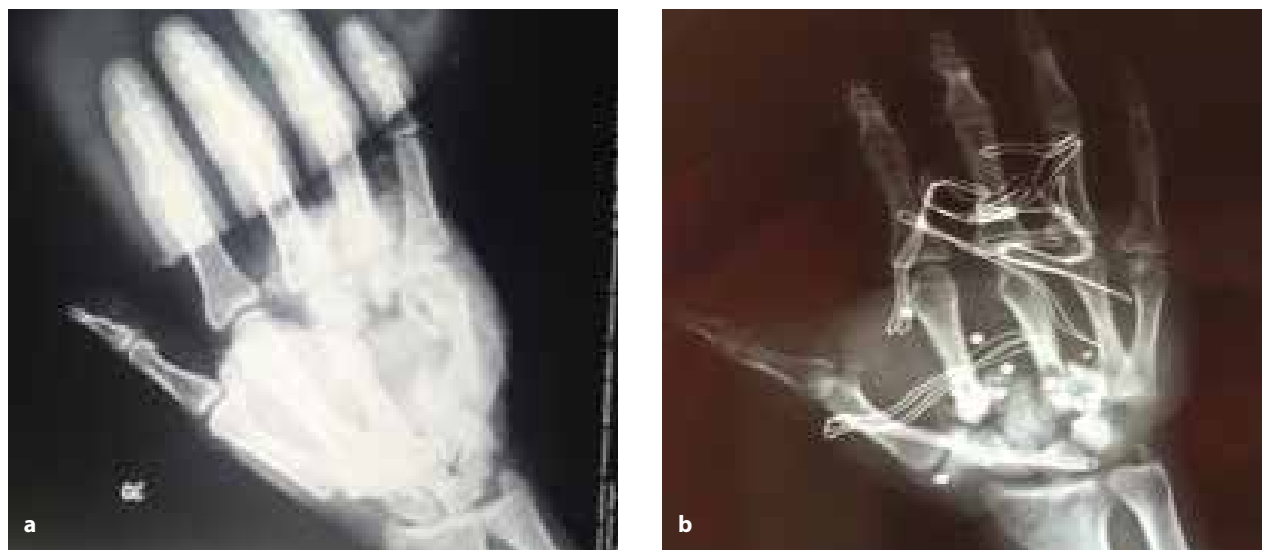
a, b. (a) Preoperative x-ray of the 4th metacarpal defect. (b) Preoperative x-ray of the carpometacarpal bone defect with foreign bodies
